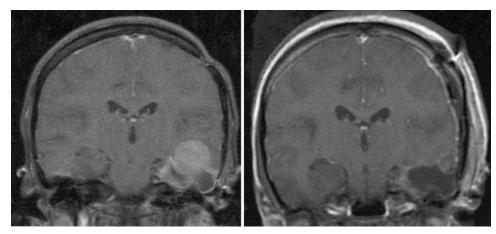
Coronal Gd-enhanced MR images. *Left:* Preoperative image revealing a dura-based enhancing lesion originating from the resection cavity in the left temporal lobe. *Right:* Postoperative image demonstrating resection of the mass with some residual enhancing tissue in the resection cavity.
